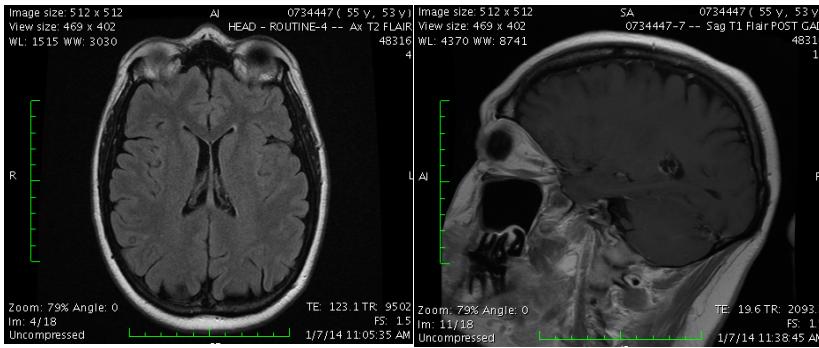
MRI of the head - no lesion at basal frontal region - January 2014
